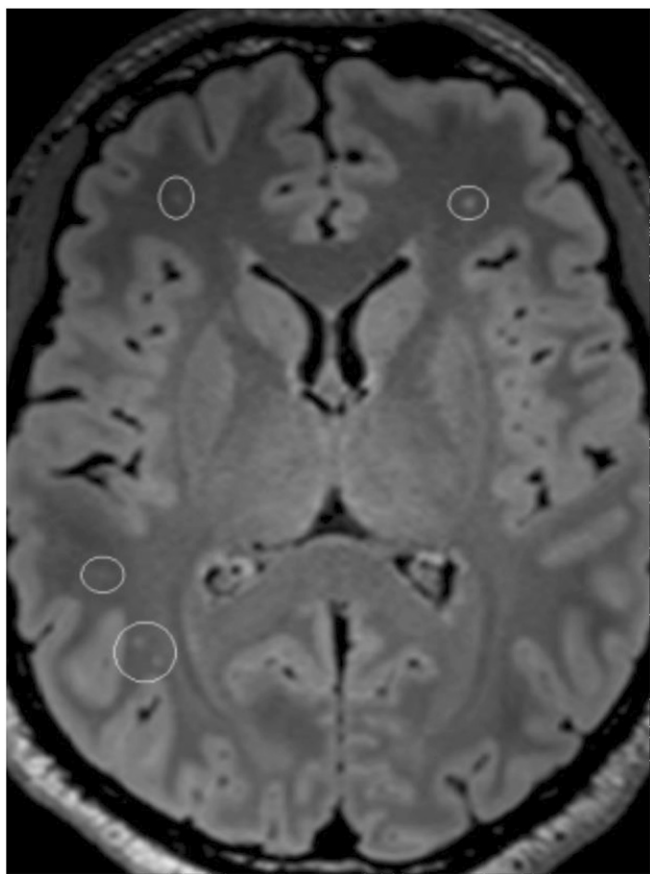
White matter hyperintensities (in a 23-yr-old male applicant). Axial fluid attenuated inversion recovery (FLAIR). The small punctiform hyperintensities (circled) are found in the white matter of the frontal and parietal lobes. A cause is often not identifiable.
